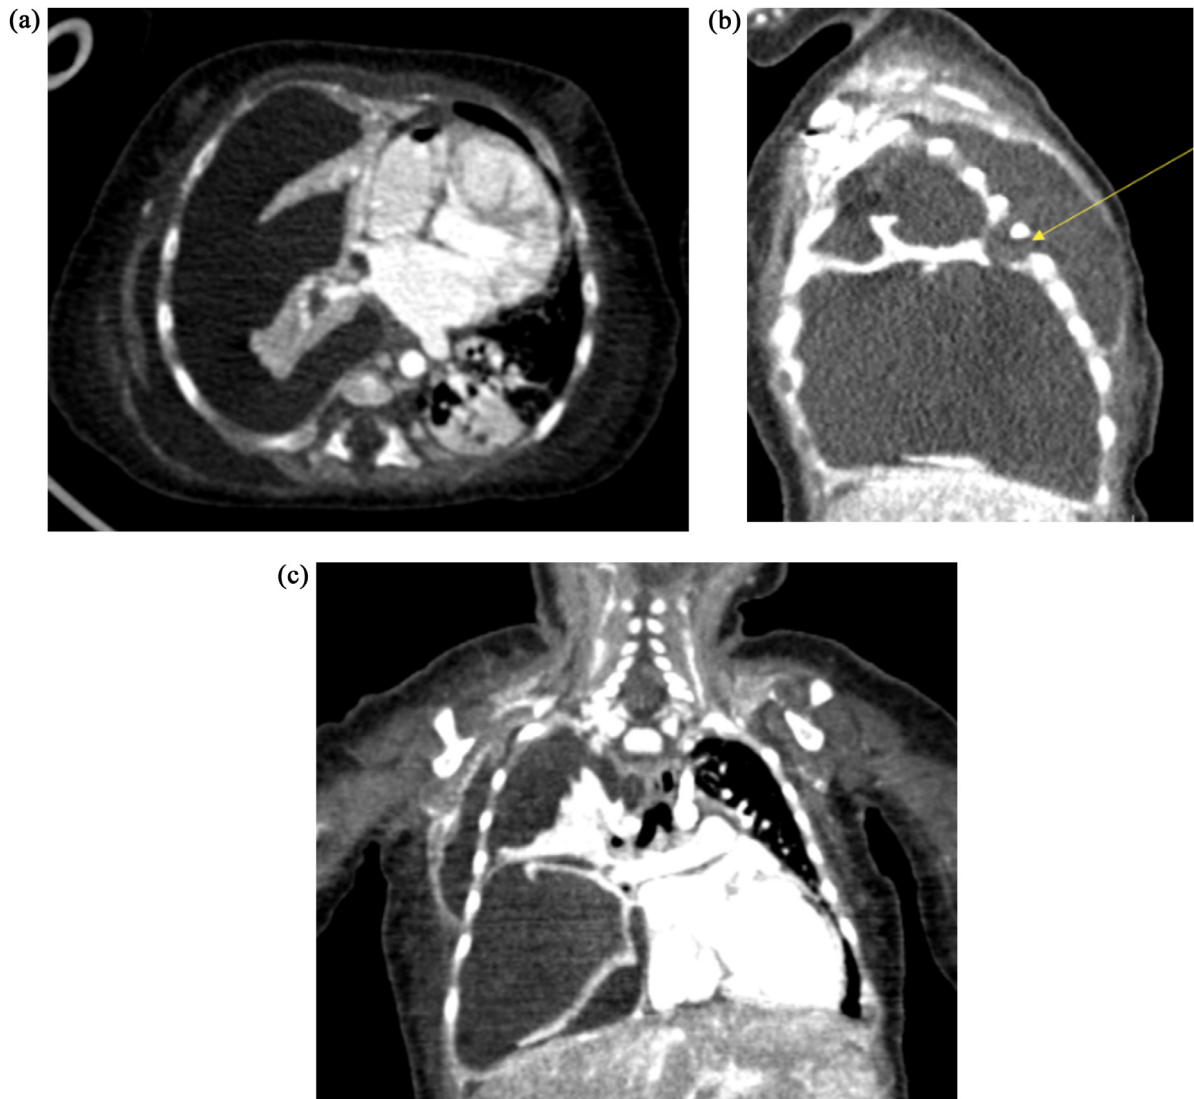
(A, B) – Axial, coronal, and sagittal contrast-enhanced chest CT shows a large right-sided pleural fluid collection with pleural thickening and enhancement, with the right lung compressed and displaced medially and consequent mediastinal shift. extra thoracic empyema was also noted. (C) A large enhancing, thick-walled abscess on the posterior aspect of the right chest wall. The yellow arrow indicates a possible communication path between intrathoracic and extrathoracic empyema.
